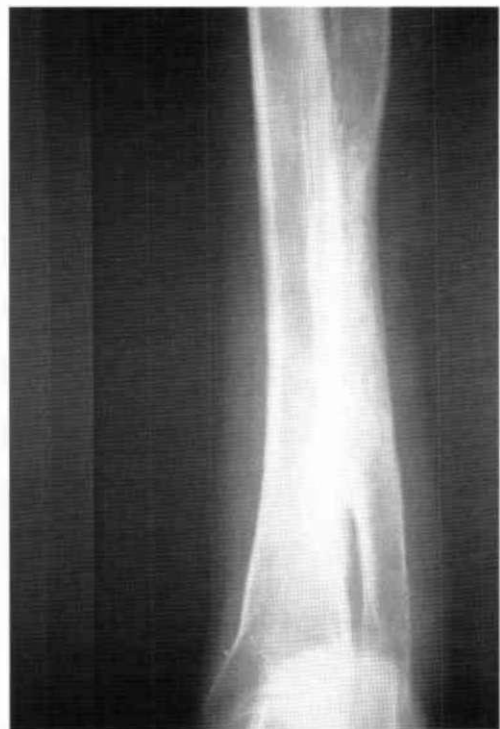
Radiographs of the left leg of a 63-year-old man, presenting with a skin cancer that developed in an ulcer spontaneously erupted three decades earlier. Note the fibular enlargement and deformity, coupled with a synostosis matching the involved leg segment. Usually complete synostosis is preceded by slow but progressive calcification of the interosseous membrane.
